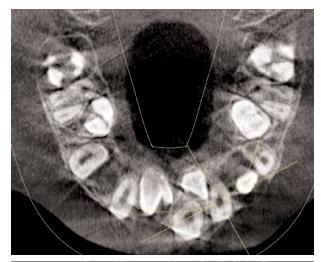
CBCT images with the presence of tuberculate and conical mesiodens
